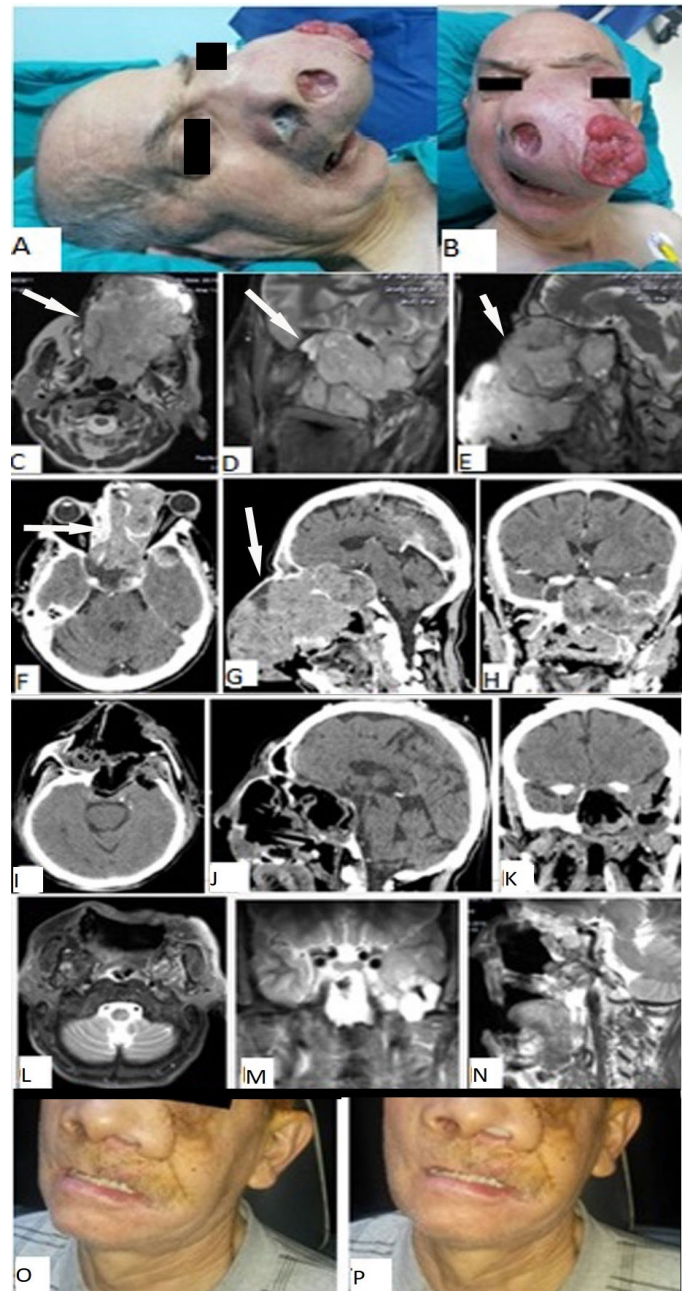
Preoperative (A, B) and postoperative photographs (O, P) of the patient. Preoperative axial (C), coronal (D), and sagittal (E) contrast-enhanced MRI showing a slightly enhancing, large, huge mass occupying the entire ventral skull base. The left side infratemporal fossa, pterygopalatine fossa, and base of the middle cranial fossa have been invaded by the tumor. Both cavernous was also involved by the tumor displacing both intracavernous internal carotid arteries superiorly and laterally. Axial (F), sagittal (G), and coronal (H) CT scans of the patient demonstrated that all ventral skull base bony landmarks were devastated by the expansile, lytic tumor. Axial (I), sagittal (J), and coronal (K) CT scans were obtained on the first postoperative day demonstrating the gross total resection of the tumor including the temporobasal component. Axial (L), coronal (M), and sagittal (N) contrast-enhanced MRI five years after the intervention, showing the continuous integrity of the skull base and no signs of recurrence. Both internal carotid arteries are in their normal anatomical location and are free from compression (white arrows=tumor)
